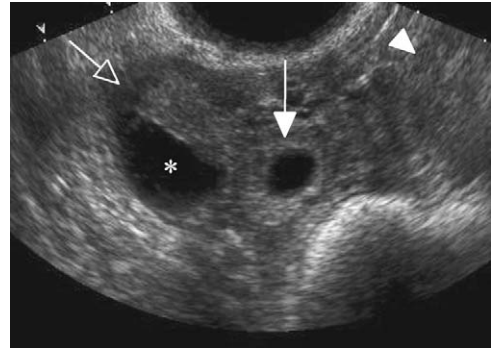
Tubal ring sign of ectopic pregnancy. Transverse ultrasound of the right adnexa shows a cystic structure with a thick echogenic rim (closed arrow), consistent with an ectopic gestational sac, located between the uterus (arrowhead) and the right ovary (open arrow), which contains a corpus luteum cyst (*).
